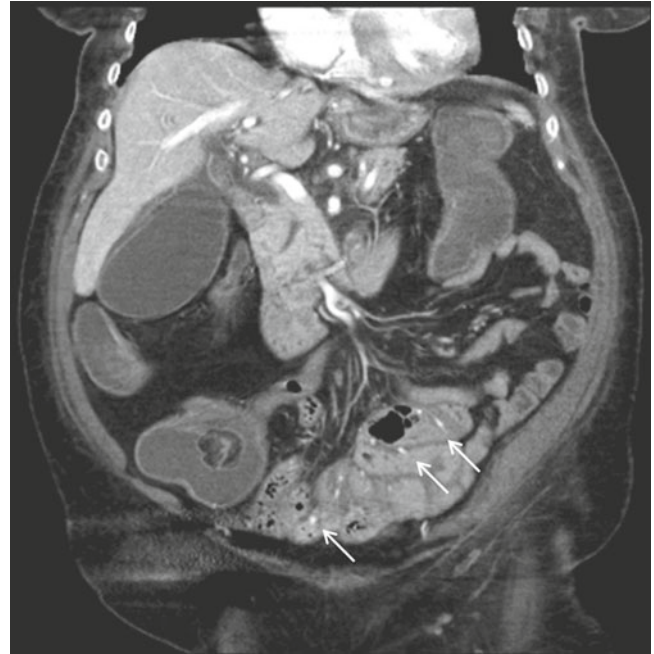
CT angiogram of 76-year-old female with end stage renal disease presenting with massive GI bleed. Coronal reformatted image showing angioectasia of small bowel evidenced by several focally dilated arteries along the small bowel wall (some indicated by arrows). No active bleeding was demonstrated during the CT angiography (CTA). Patient recovered with conservative treatment and the diagnosis was confirmed later with double balloon endoscopy
